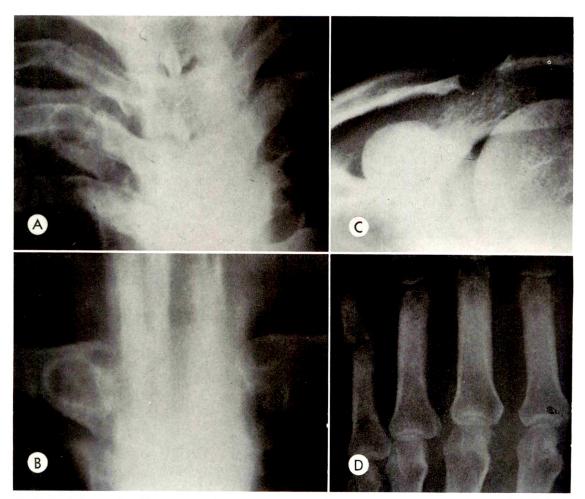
(A) Conventional anteroposterior roentgenogram of the sternoclavicular joints of a 35 year old female with rheumatoid arthritis. Skeletal survey revealed involvement of the wrists, shoulders, ankles and knees. The clavicular heads are indistinct. A radiolucent focus is present in the head of the right clavicle. (B) Laminagram of the same patient. Radiolucent foci are present in the heads of both clavicles. Moderate subchondral bone resorption is present in the inferior aspects of both clavicular heads. Slight sclerotic changes are present in the upper portions of both clavicular heads. (C) Same patient. The acromial end of the clavicle presents a sharply demarcated erosive change. (D) Same patient. The arthritic changes involve the small joints of the hands, with destruction of the articular surfaces particularly prominent in the fifth proximal phalangeal joint.
